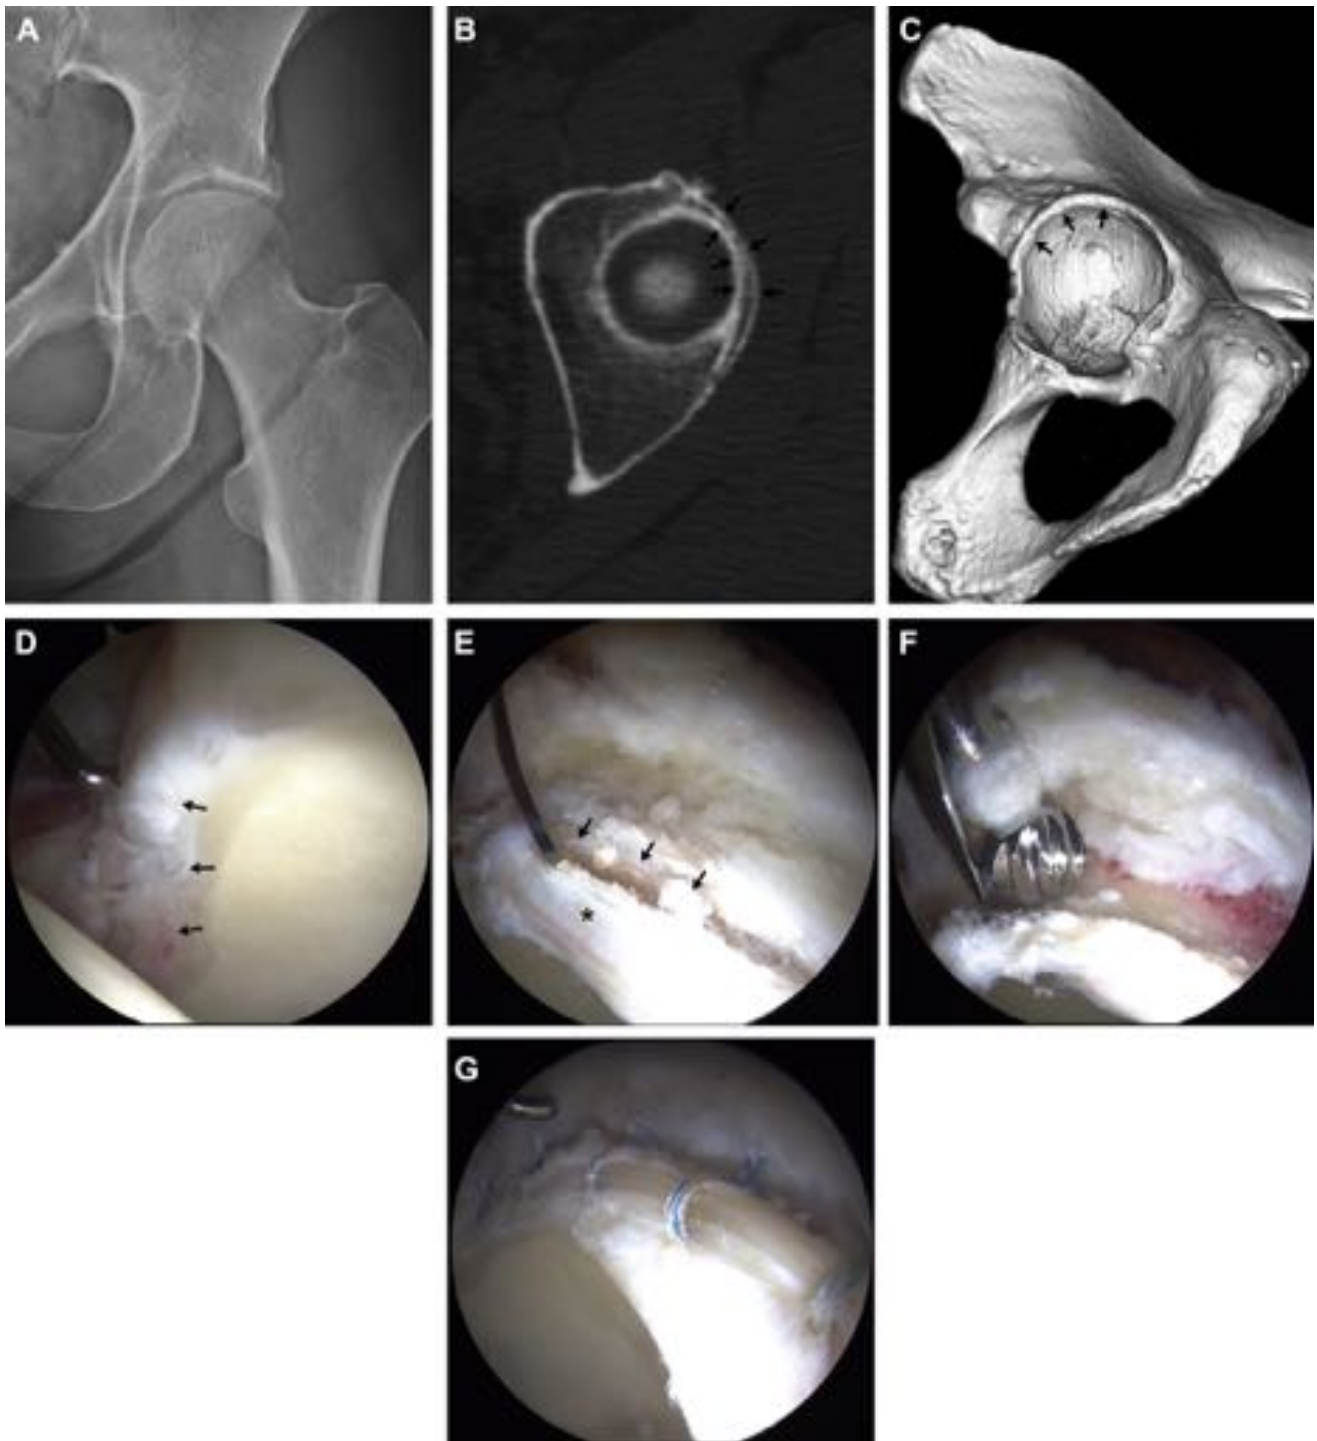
A 46-year-old woman with recalcitrant painful range of motion left hip with temporary response to an intra-articular injection and unremarkable MRI. (A) AP radiographic view unremarkable, with CE angle of 42°. (B) Axial CT scan reveals the “double rim sign” of the acetabulum (arrows), often indicative of labral ossification. (C) Three-dimensional CT reconstruction image reveals thickening acetabular rim (arrow), further indicative of labral ossification. (D) Arthroscopic view from the anterolateral portal reveals substantial tearing of the labral remnant (arrows). (E) An arthroscopic knife is used to sharply mobilize the labral remnant (asterisk) from the ossified portion (arrows). (F) Acetabuloplasty is performed with a 5.5-mm burr excising the ossified portion of the labrum. (G) The labrum has been refixed with 5 suture anchors. Because of the hypoplastic nature of the labral remnant, simple loop sutures were used to restore the labrum to the rim. (CE, center edge; CT, computed tomography; MRI, magnetic resonance imaging.) (copyright, J.W. Thomas Byrd, M.D., 2014).
